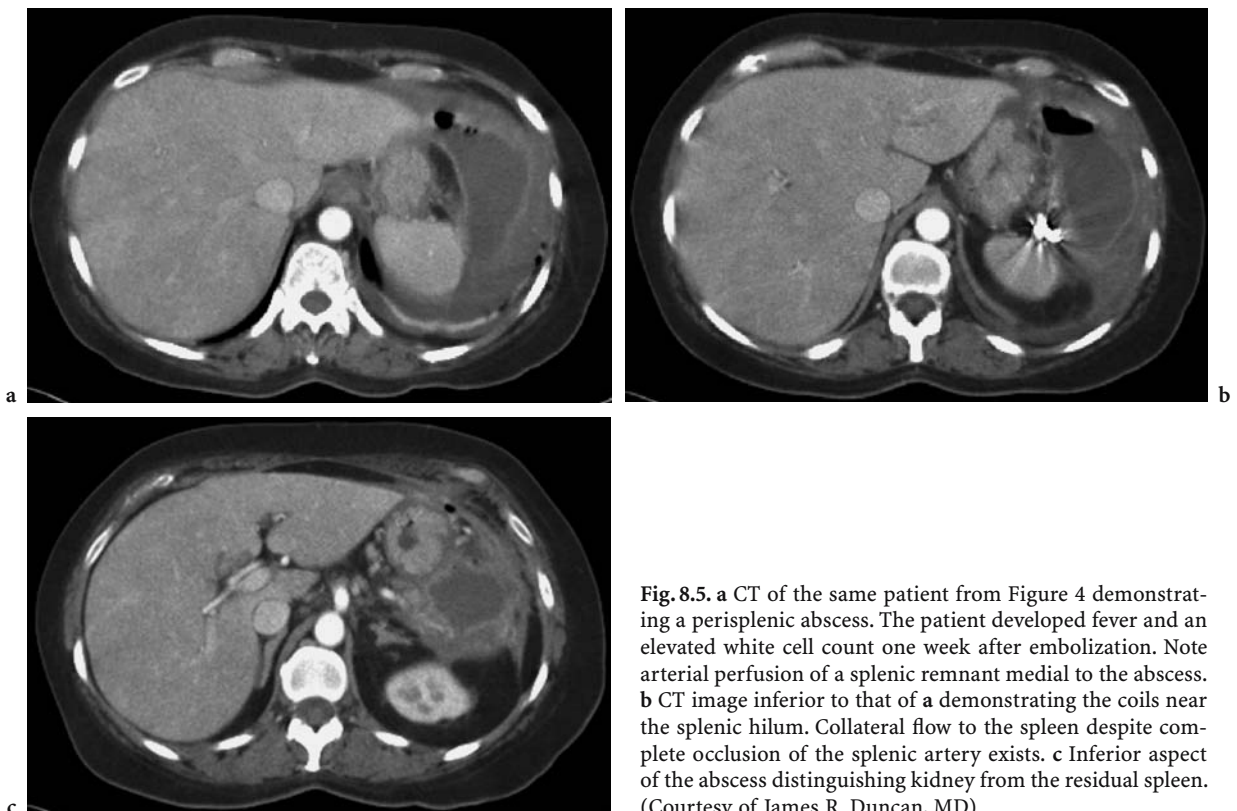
a CT of the same patient from Figure 4 demonstrating a perisplenic abscess. The patient developed fever and an elevated white cell count one week after embolization. Note arterial perfusion of a splenic remnant medial to the abscess. b CT image inferior to that of a demonstrating the coils near the splenic hilum. Collateral flow to the spleen despite complete occlusion of the splenic artery exists. c Inferior aspect of the abscess distinguishing kidney from the residual spleen. (Courtesy of James R. Duncan, MD)
